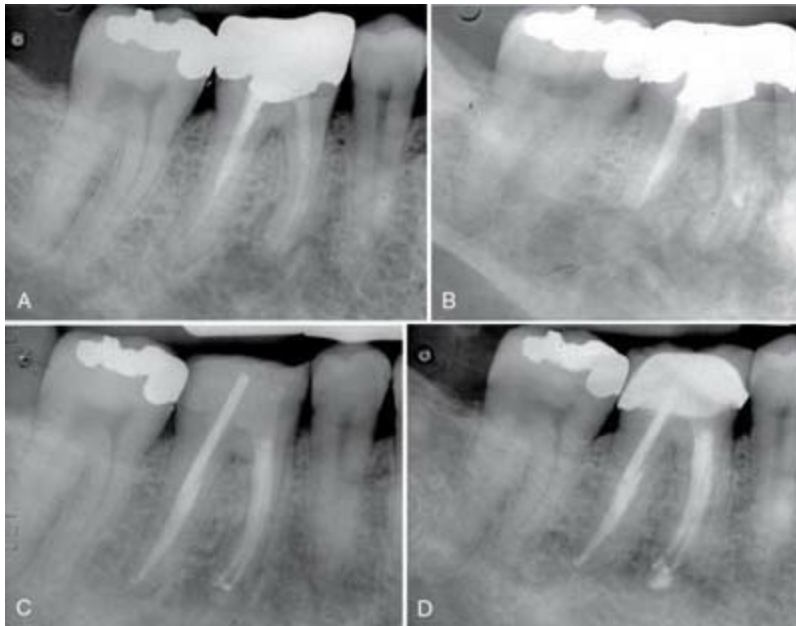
A, Posttreatment disease. Previous endodontic therapy performed 3 years previously. B, Distal angle radiograph reveals asymmetry indicating the presence of an untreated mesiobuccal canal. C, Immediate postobturation film showing treated MB canal. D, Fourteen-month postoperative view. The patient was asymptomatic.
